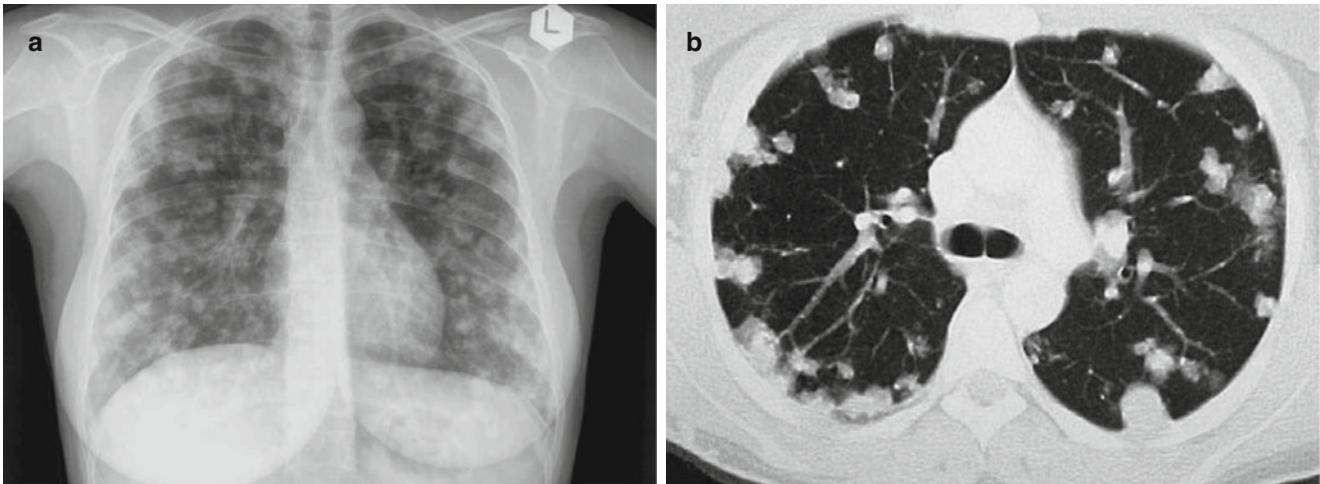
Alveolar echinococcosis. (a) X-ray demonstrates diffuse patches of shadows in both lungs, with irregular and poorly defined boundaries. (b) CT scanning demonstrates plum blossom-like nodules with increased density and different sizes in both lungs
